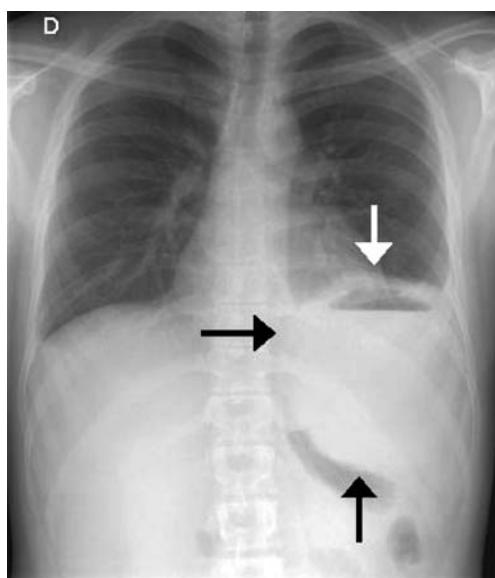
Chest radiograph showing signs of a prominent splenic abscess with air fluid level and stomach displacement
